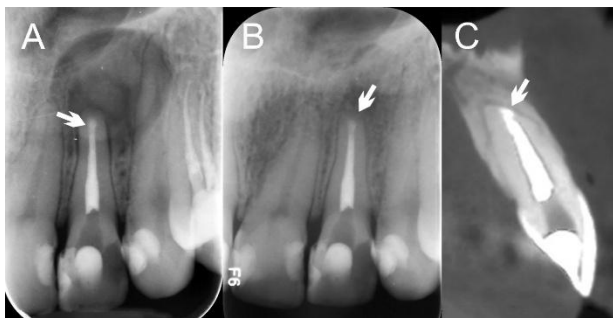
Progressive enlargement of a persistent periapical lesion associated with tooth #22. (A) Initial periapical radiograph showing a well-circumscribed, unilocular radiolucency (approximately  $8 \times 8$  mm; indicated by white arrows) at the apex of tooth #22, suggestive of a periapical lesion despite previous root canal treatment. (B) One-month postoperative radiograph following nonsurgical retreatment reveals a slight increase in lesion size (approximately  $9 \times 9$  mm; indicated by white arrows), confirming a lack of healing. (C) Eight-month follow-up radiograph demonstrating further enlargement of the lesion (approximately  $11 \times 11$  mm; indicated by white arrows), consistent with treatment failure and suggestive of a true radicular cyst unresponsive to orthograde endodontic retreatment.
